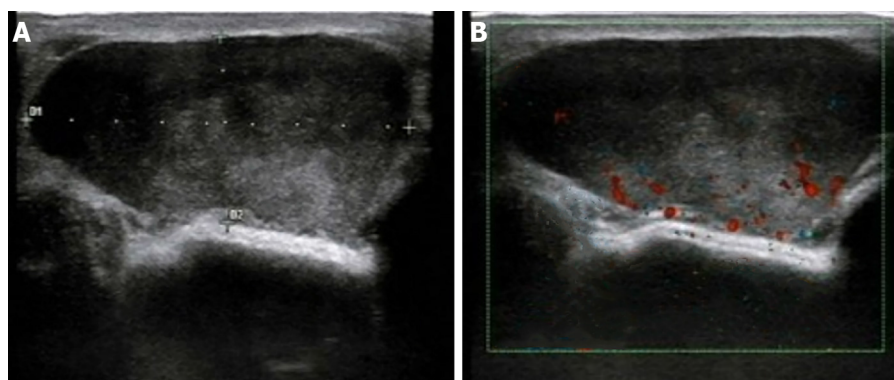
Ultrasound manifestations of inflammatory myofibroblastic tumor. A: An oval, hypoechoic mass with clear borders of approximately 4.2 cm × 1.8 cm in size was identified at the 9 o'clock position in the left breast. The internal echo was heterogeneous, with scattered small fleck echo and slightly enhanced rear echo; B: Color Doppler flow imaging indicated limited blood flow signal within the hypoechoic mass.
